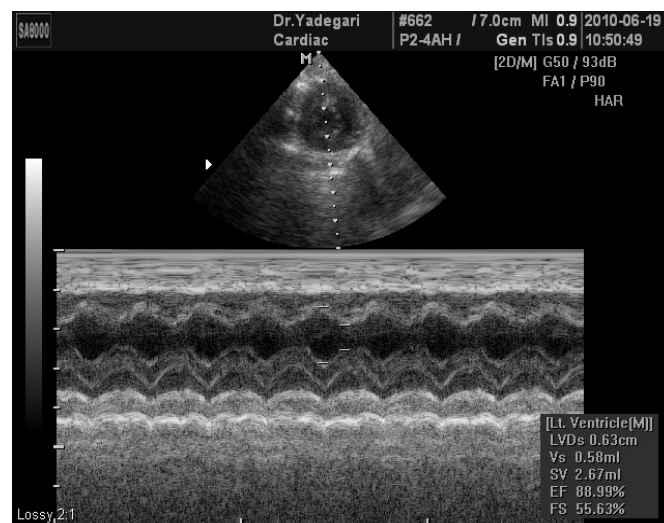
Evaluated and measured of echocardiography indexes by M-mode and 2D methods
